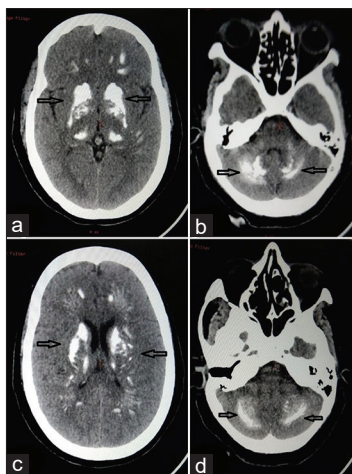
(a-d) Noncontrast computed tomography scan brain axial cuts showing bilateral symmetrical calcification in strio-pallido-dentate area
